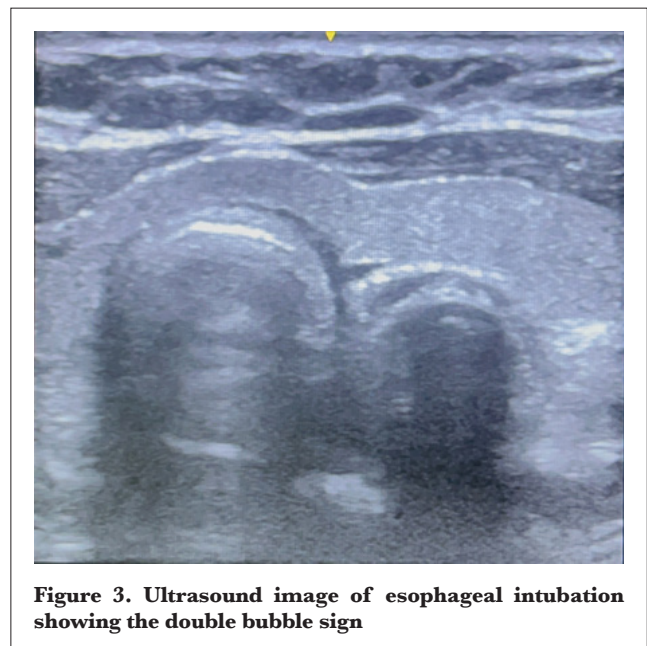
Ultrasound image of esophageal intubation showing the double bubble sign
